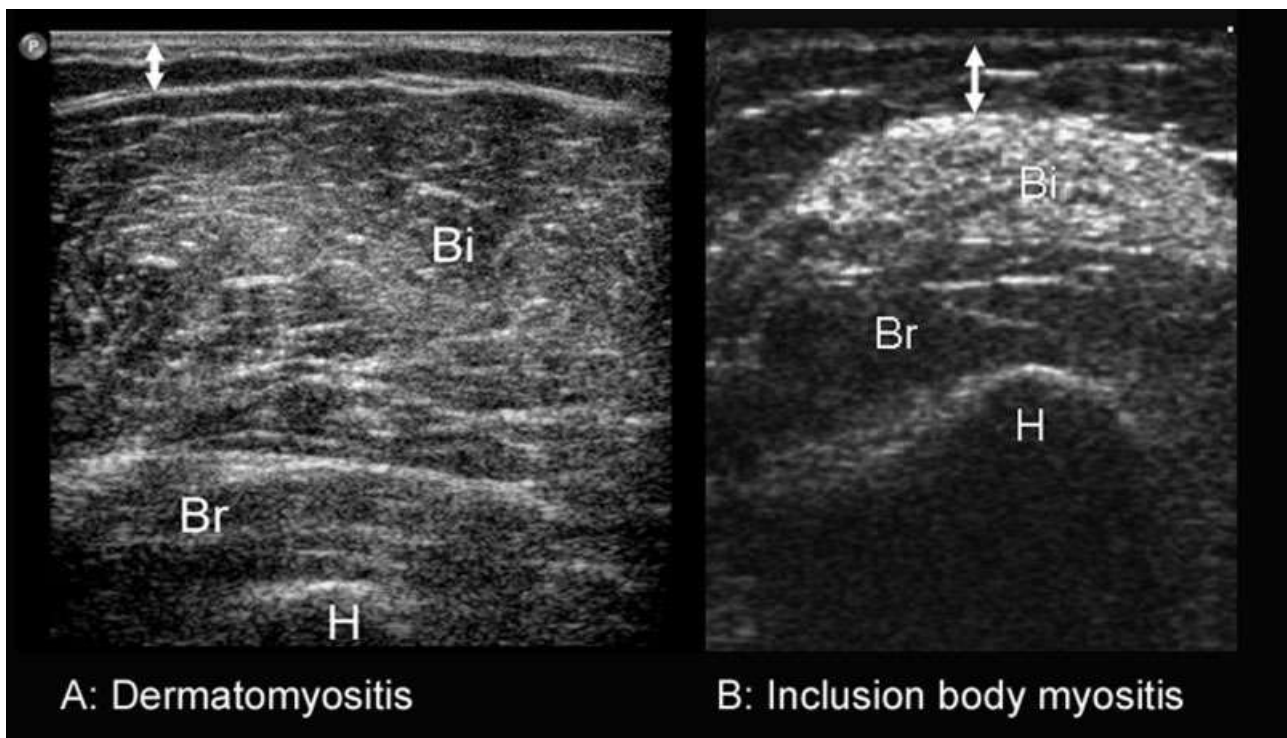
Ultrasound image of the biceps brachii and brachialis muscle at two thirds of the distance from the acromion to the antecubital crease in a 55-year-old man with acute, untreated dermatomyositis (A) and a 65-year-old man with inclusion-body myositis (IBM) (B). In (A), a moderately increased echo intensity is visible with an inhomogeneous, patchy appearance. The muscle thickness is normal. Conversely, the IBM patient (B) has severe atrophy and selective muscle involvement. The biceps brachii muscle shows a very high echo intensity, whereas the brachialis muscle appears normal. The difference in resolution of both images is caused by a difference in transducers: the left image is made with a broadband 5–17-MHz transducer, whereas in the right image a phased-array 7.5-MHz transducer was used. Bi, biceps brachii muscle; Br, brachialis muscle; H, humerus; double arrow, subcutaneous tissue.
